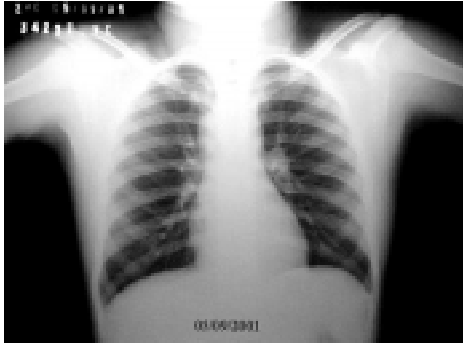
Chest X-ray (frontal view): large mass in the upper right mediastinum, measuring 5 cm in its largest diameter.
